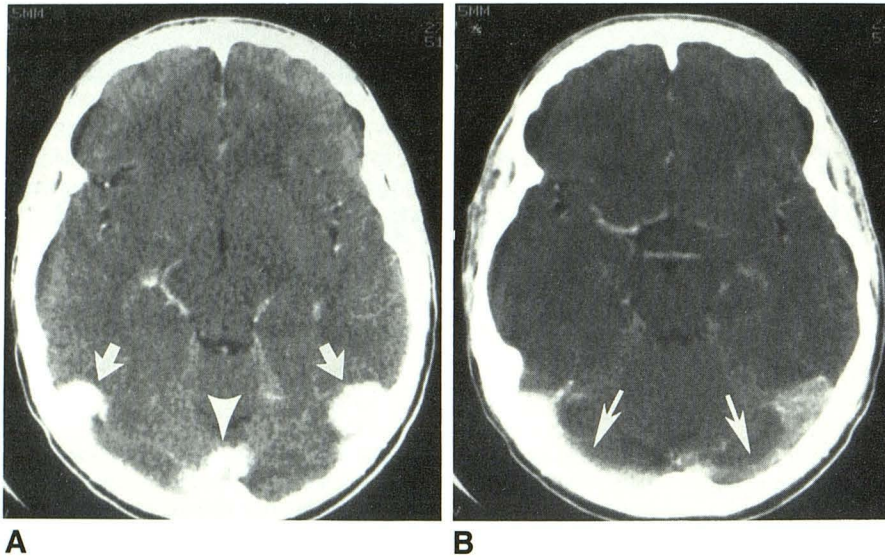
A, Axial enhanced CT scan shows nodular densities bilaterally near tentorial insertion (arrows). Ill-defined density centrally also was present (arrowhead).
